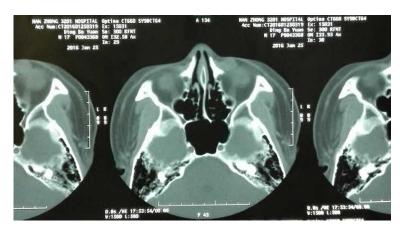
CT scan depicting a homogeneous mass situated near the left eyeball without bony invasion.
